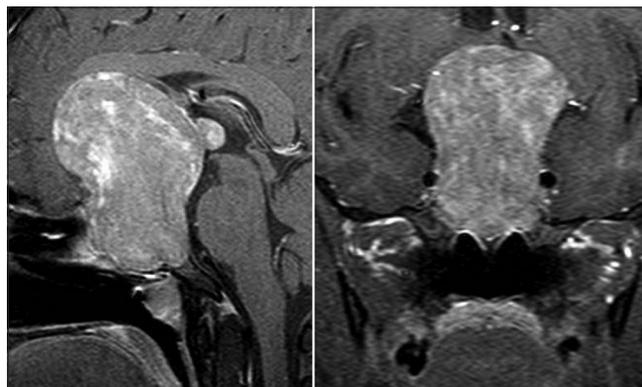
Sagittal (left) and coronal (right) results from gadolinium-enhanced T1-weighted magnetic resonance imaging
